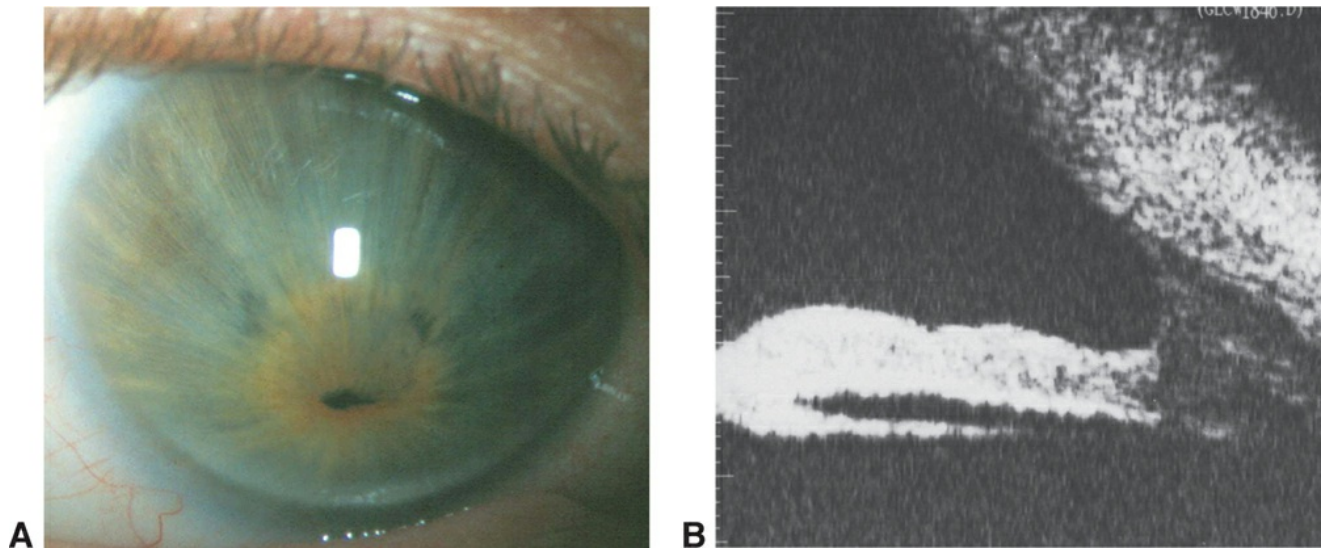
A, Ectopia lentis et pupillae. B, Ultrasonography shows a membrane posterior to the iris attaching at the pupil margin. (Part A reproduced from Byles DB, Nischal KK, Cheng H. Ectopia lentis et pupillae. A hypothesis revisited. Ophthalmology. 1998;105(7):1331–1336. Part B courtesy of Ken K. Nischal, MD.)
